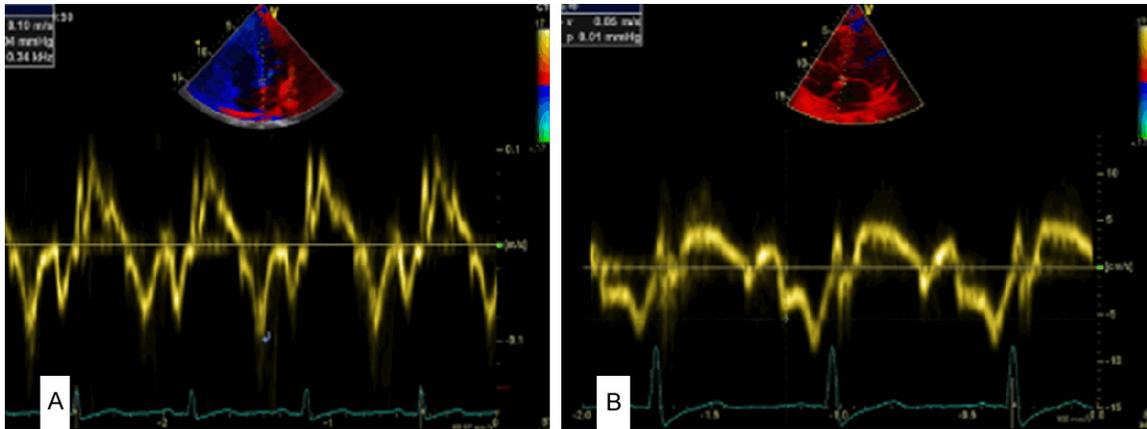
Septal mitral annulus tissue Doppler early velocity e' of women with severe PE compared with healthy pregnant women. Septal mitral annulus tissue Doppler early velocity e' of women with severe PE (B) decreased as compared with healthy pregnant women (A).
